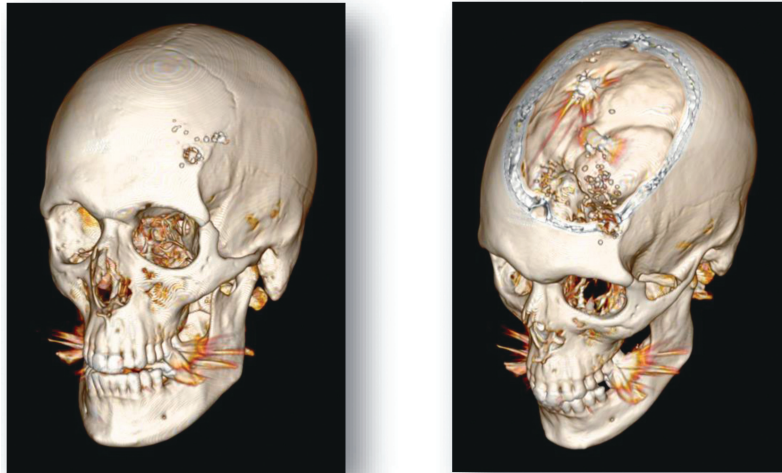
Example of postmortem computed tomography images of trauma cases: Gunshot injury to the head showing entrance wound to the left side of frontal bone with projectile path to the right side of cranial cavity.
